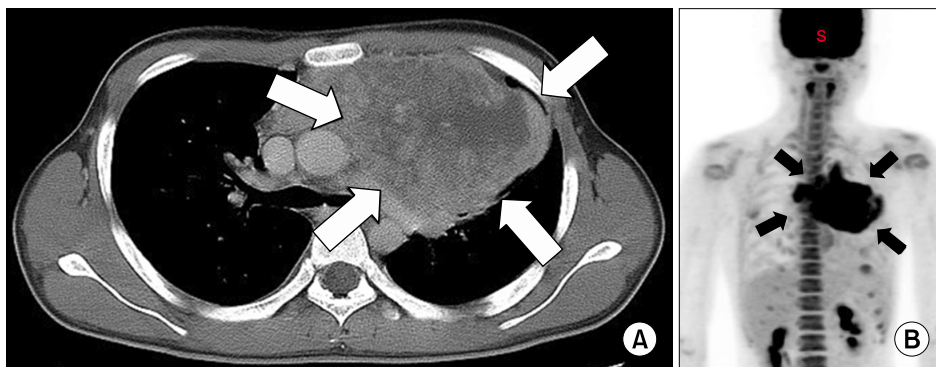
Chest CT (A) showing a large heterogeneous mass in the anterior mediastinum (white arrow), PET-CT (B) with intense FDG uptake in the anterior mediastinum, consistent with malignancy (black arrow).
